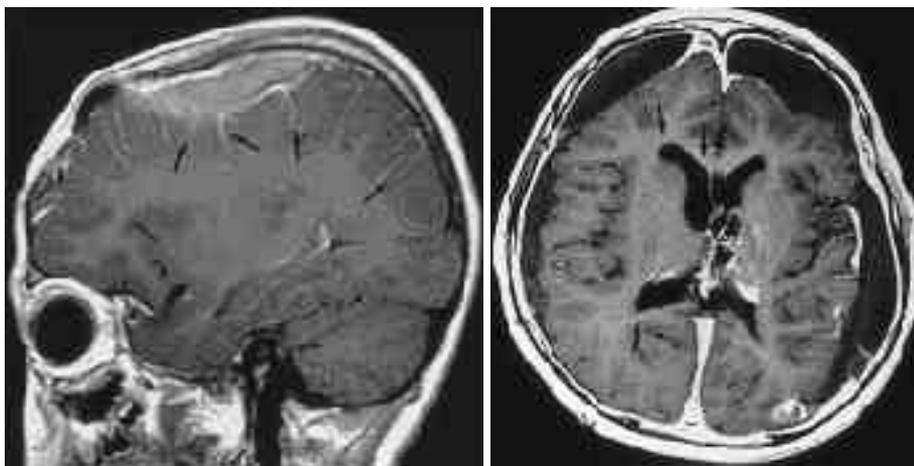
Infectious meningeal enhancement. Enhanced T1-weighted sagittal MR image shows abnormal leptomeningeal enhancement (arrows) in the frontal and parietal lobes, extending deep into the brain sulci. Overlying subdural high signal intensity area was proved to be pus mixed with hemorrhage at surgery.
